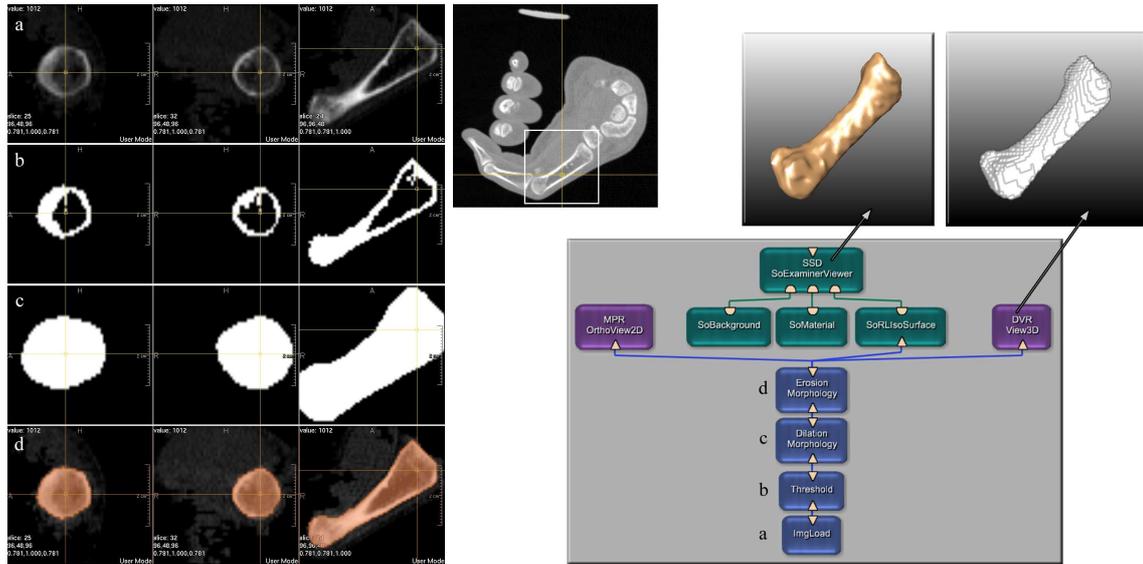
Segmentation of a single bone from a wrist CT data set (volunteer) in three successive steps. *a*: Original data in orthogonal sections; all other bones (cf. scout image) were excluded using a watershed transform. *b*: Results after thresholding. *c–d*: 3D morphological closing, i. e. dilation (*c*) and erosion (*d*). *right*: MeVisLab network for segmentation of a single bone (steps *a–d*). The result after morphological closing (*c+d*) is also shown in 3D as Shaded Surface Display (SSD) using marching cubes and via Direct Volume Rendering (DVR).
